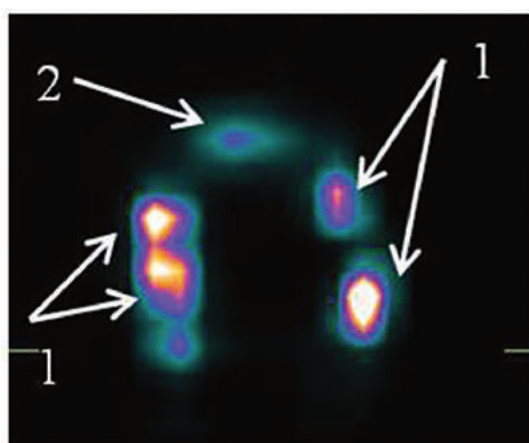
SPECT image of a patient with laryngopharyngeal cancer: 1 – radiopharmaceutical uptake in the projection of the lymph nodes of the neck on both sides ( $n = 5$ ); 2 – injection site
